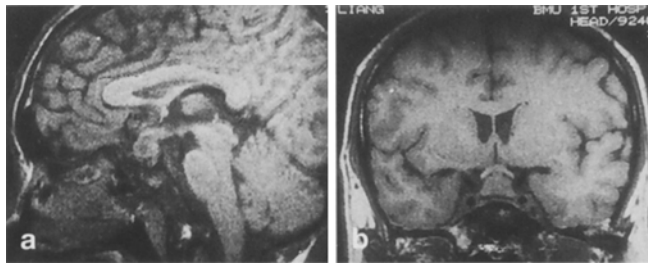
a, b Sagittal and coronal T1-weighted images show enlargement of entire pituitary gland with inhomogeneous low signal intensity and chiasmal compression. c Sagittal contrast-enhanced image reveals uniform enhancement of the lesion and of the stalk and adjacent meninges in addition
